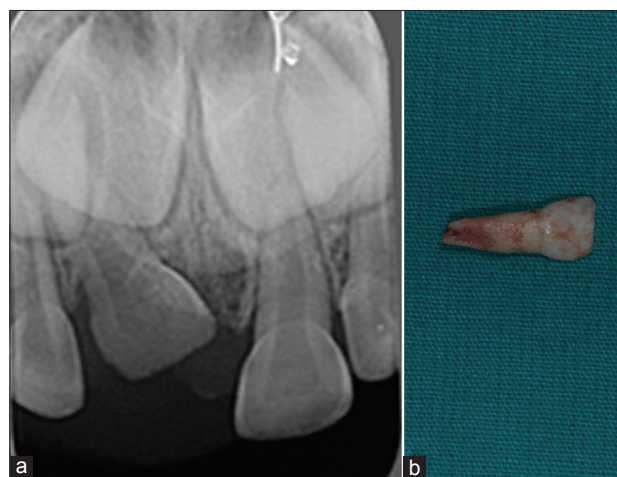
(a) Periapical radiograph showing severely intruded primary maxillary right incisor; (b) surgically extracted deciduous tooth
